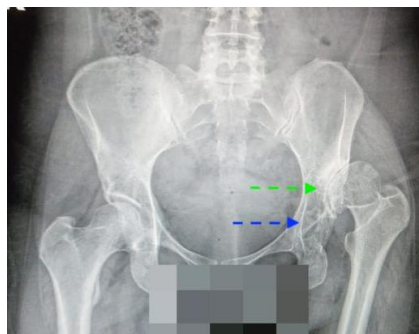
Preoperative x-ray of both hips in an anterior-posterior view. Complete dislocation of the left femoral head to cranial. Neo-acetabulum formed (green arrow) above the original acetabulum (blue arrow) on the left side. Classified by Hartofilakidis(6) as B.
